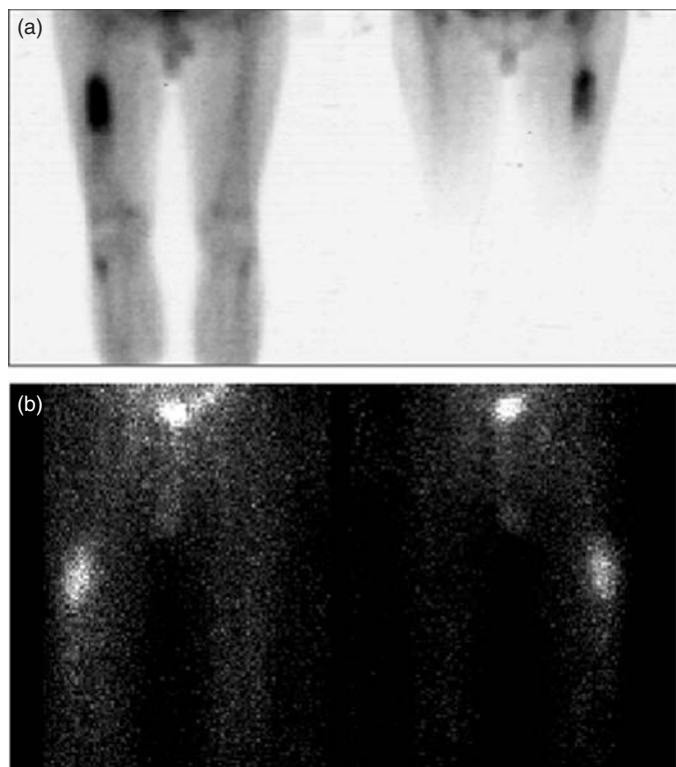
PSMA expression in non-prostate cancer. (a) Traditional bone scan demonstrating bilateral activity in the femur indirectly indicating the presence of metastatic renal cell carcinoma. (b) ^{111}I -huJ591_{EXT} diagnostic immunoscintiscan of the same patient showing direct localization of the anti-PSMA antibody conjugate to the sites of metastatic renal cell carcinoma that feature PSMA expression in the tumor neovasculature. Reprinted from Ross, J.S. and Foster, C.S. eds. *The Molecular Oncology of Prostate Cancer*. 2006. Sudbury, MA: Jones and Bartlett, Inc. with permission by the publisher.
